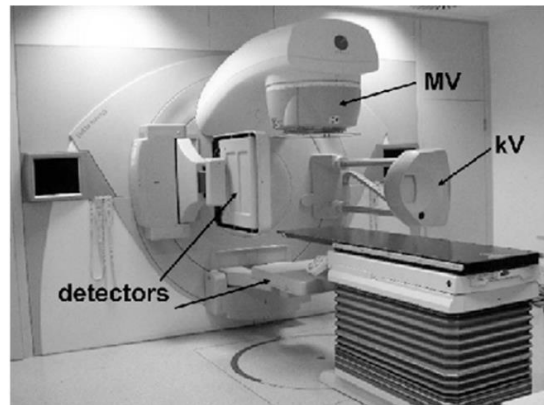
Elekta Synergy linear accelerator with integrated cone beam computed tomography [76]
